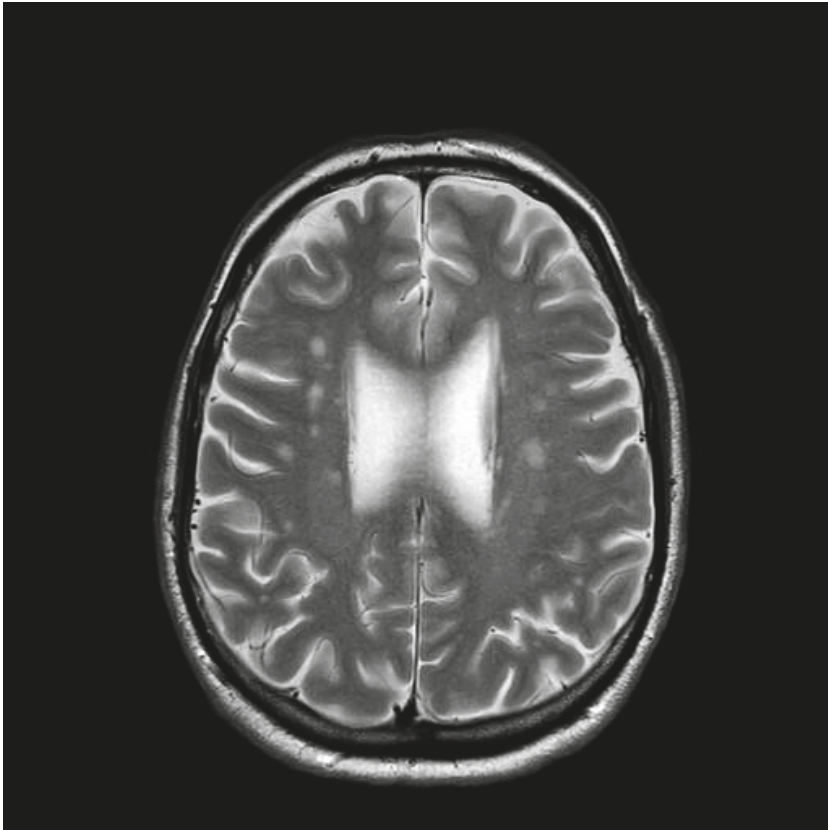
Brain Magnetic resonance imaging (MRI) scan conducted on presentation in 1997. The patient was diagnosed with gluten encephalopathy, having presented with headaches and cognitive difficulties. Serological testing and subsequent duodenal biopsy confirmed celiac disease (CD). The scan shows white matter changes typical of what is seen in the context of gluten encephalopathy.
